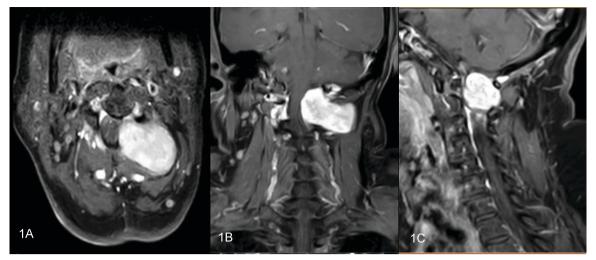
Preoperative axial (A), coronal (B), and sagittal (C) contrast-enhanced MRI image showing a large, dumbbell-shaped extramedullary tumor located intra- and extradural, involving the left C1–C2 neural foramina and compressing the spinal cord.
